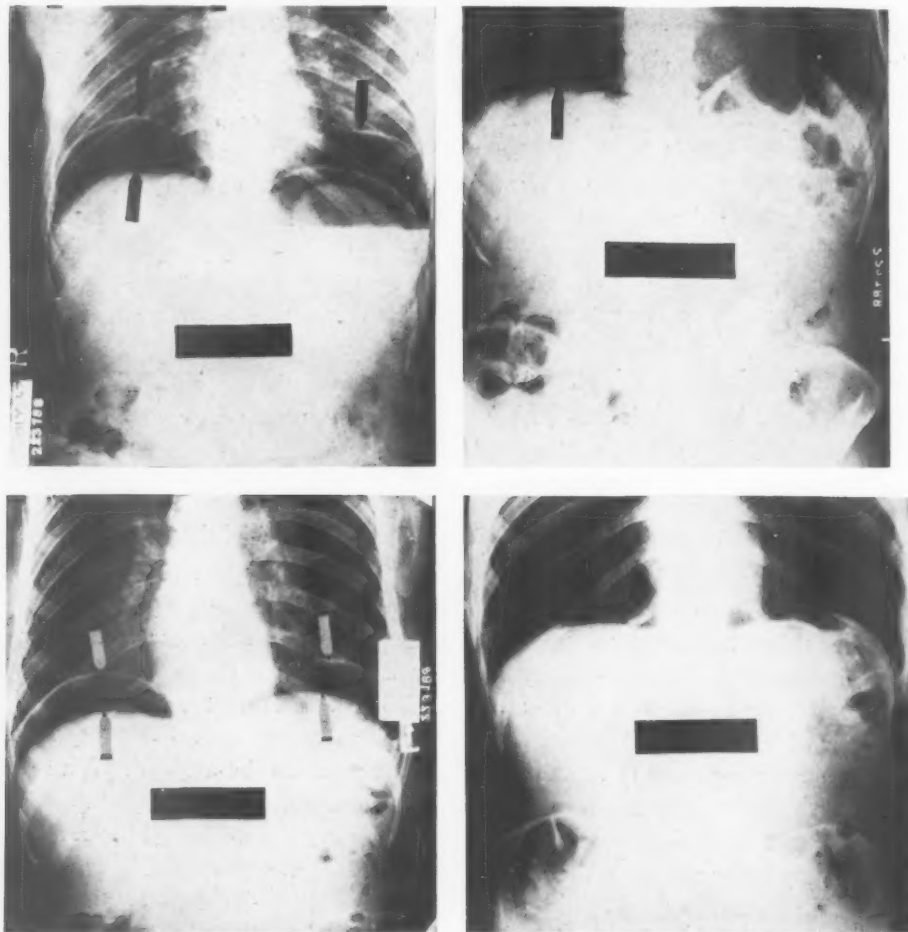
Roentgenograms of Case 12 showing the largest collection of free intraperitoneal air in this series. The upper left film was taken on admission; the lower left three days after admission; the upper right was taken seven days after admission and the lower right nine days after admission. On the tenth day no free air was demonstrable.
